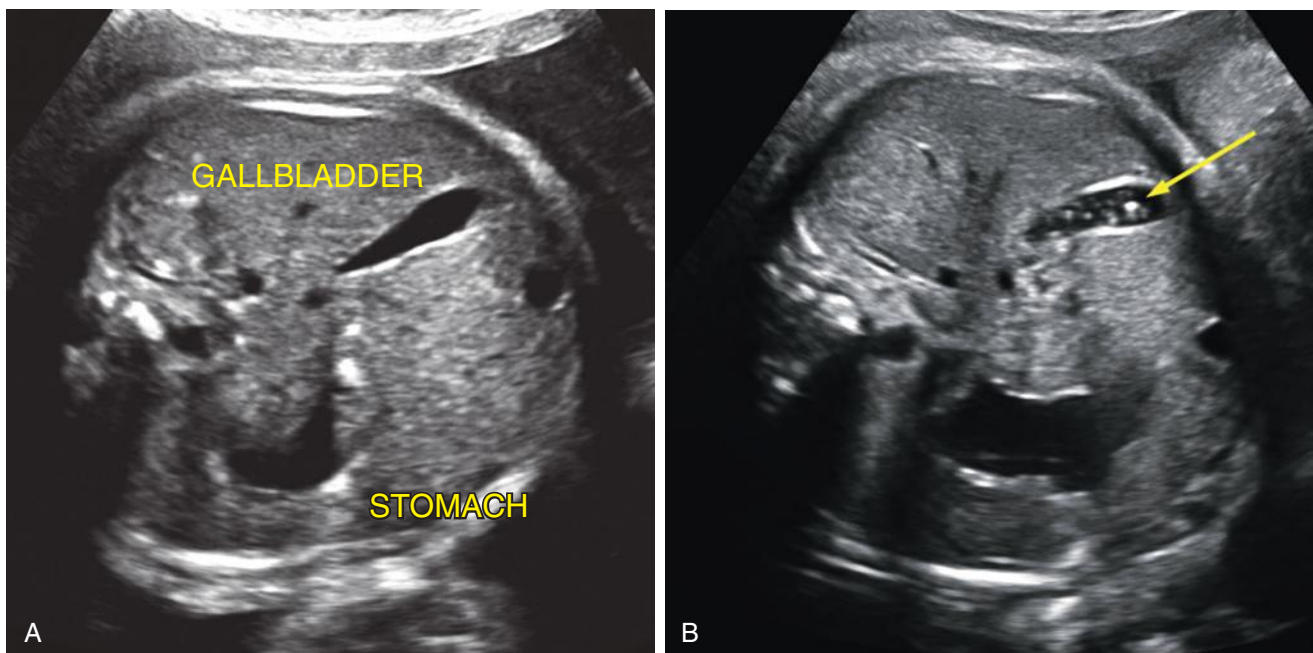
Gallbladder. A, Normal fetal gallbladder in the third trimester. B, Similar transaxial sonographic view of the upper abdomen in a different fetus showing gallstones (*arrow*), which are relatively common and usually resolve spontaneously after birth.
